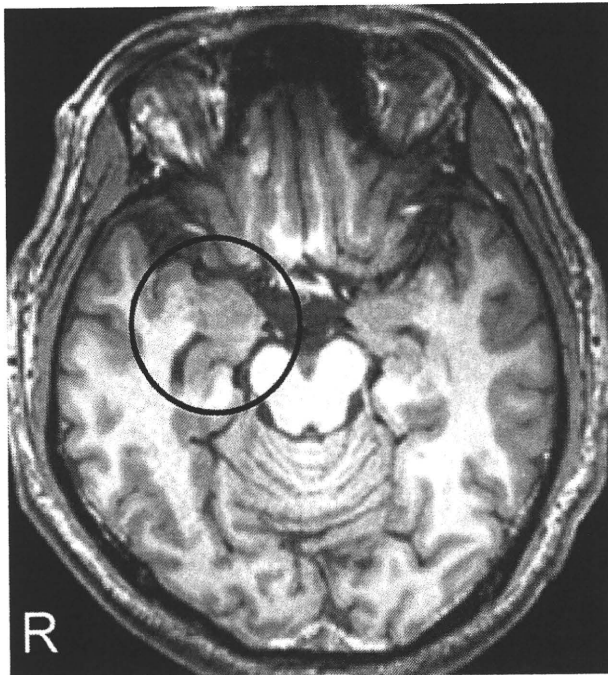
Axial T1 weighed MRI in patient No 9. Open circle indicates a representative image of right amygdalar enlargement. The intensity of the amygdala does not show laterality. No abnormal lesions were found in areas adjacent to the amygdala.
